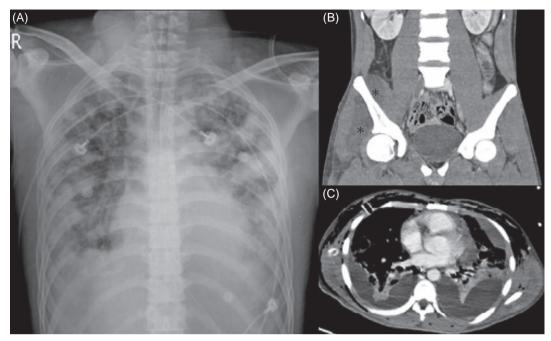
(A) The chest radiograph shows opaque diffuse nodules in both the lungs. (B) Coronal computed tomogram shows enlargement and decreased attenuation of the right iliacus and gluteal muscles (asterisks) and effacement of the fat planes, which suggest infectious myositis. (C) Contrast-enhanced computed tomogram shows loculated pleural fluid and split-pleura sign (which indicate exudative pleural effusion), subcutaneous emphysema in most anterior region of the chest wall, and small cavitary lesions in both the lungs.
